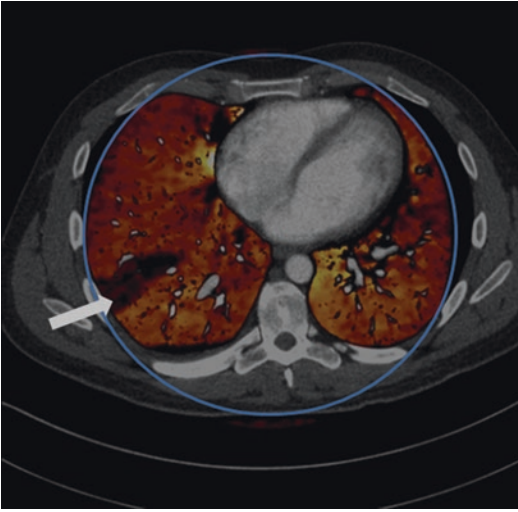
Axial image of a patient with a pulmonary embolism and large perfusion deficit (arrow). In this image, the iodine signal is colored between red and yellow, with yellow denoting higher iodine concentrations. The absolute value of iodine concentration can be measured using provided tools. This image is from a dual-source CT system, which has a smaller field of view for the second tube-detector pair. Beyond that field of view (blue circle), only single-energy information is shown (Reprinted with permission from [15])
